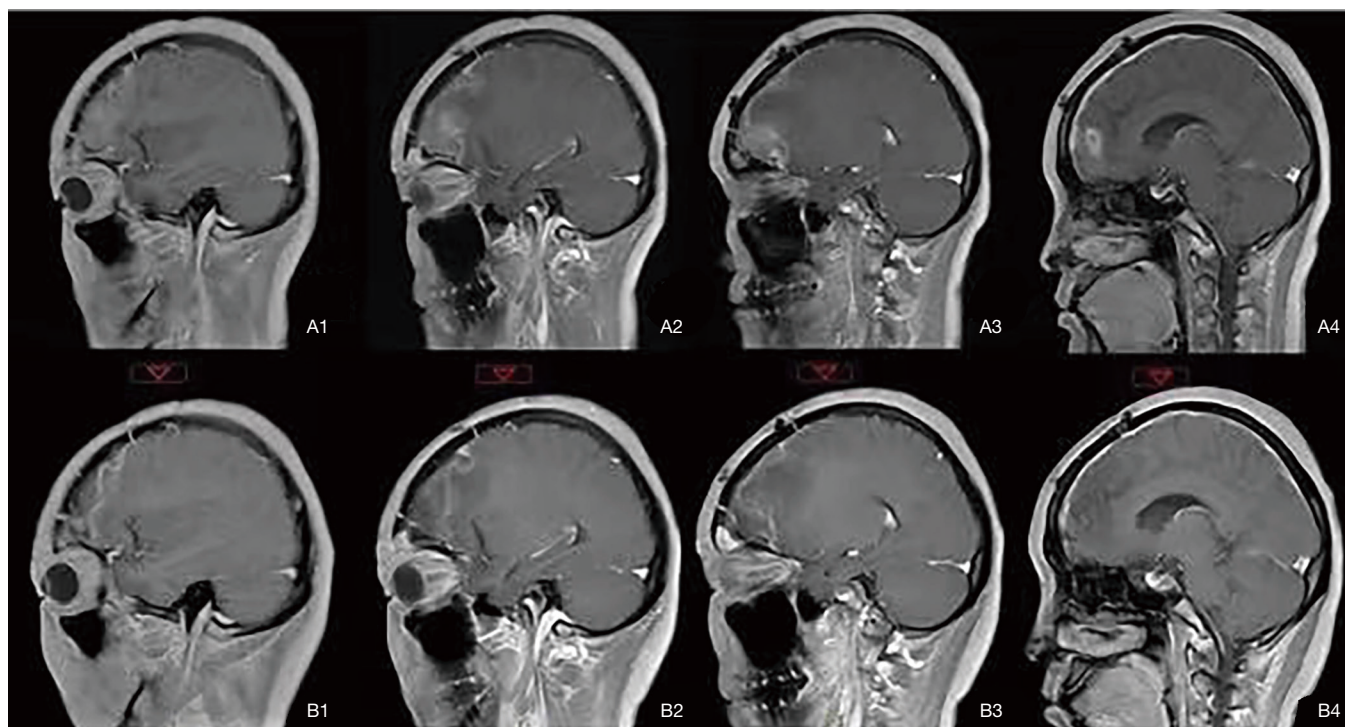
Magnetic resonance imaging of the brain, T1-weighted image. Sagittal section, before (A1-A4) and after (B1-B4) radiotherapy.
